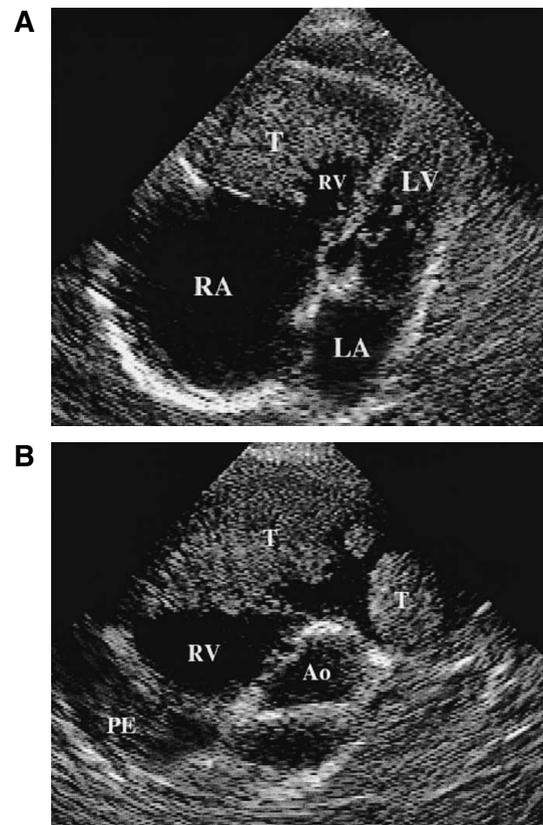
Two-dimensional echocardiograms. (A) Apical 4-chamber view and (B) short axis view demonstrate a large mass in the right ventricle attached by a stalk below the pulmonary valve. RA, right atrium; RV, right ventricle; LA, left atrium; LV, left ventricle; Ao, aorta; PE, pericardial effusion; T, tumor.
